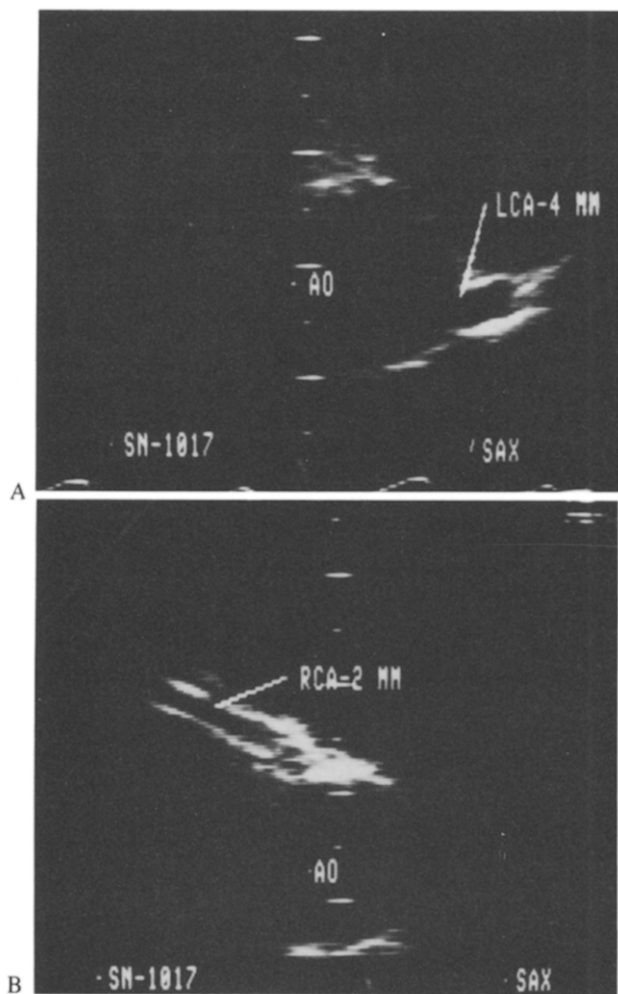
Two-dimensional echocardiogram of the coronary arteries of a 3 year old patient with Kawasaki disease but no aneurysms showing (A) a left coronary artery (LCA) dimension at the upper limit of normal (4 mm) and (B) a right coronary artery (RCA) dimension at the lower limit of normal (2 mm). AO = aorta.
